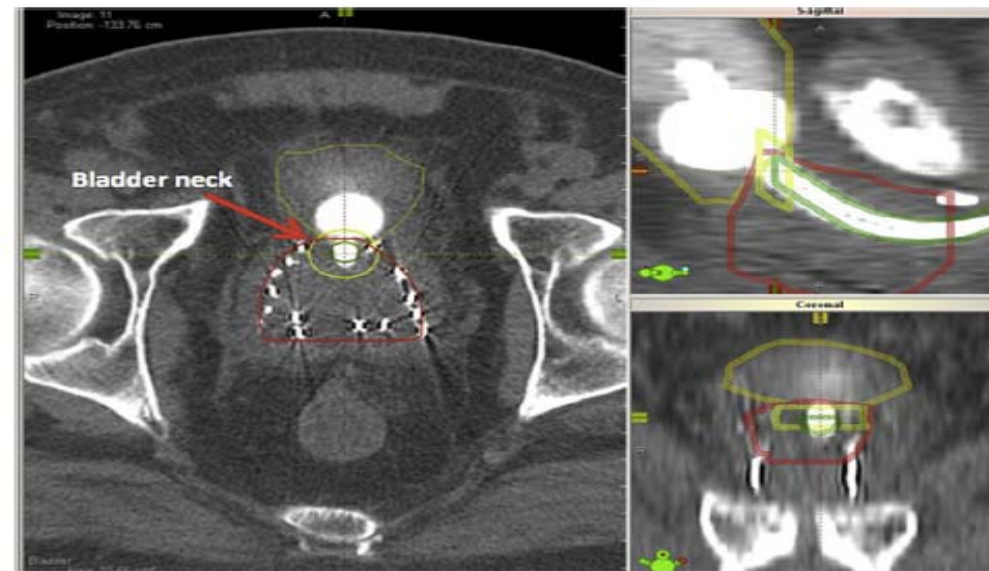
Contour of bladder neck on computed tomographic scan on day 0 after implantation.
